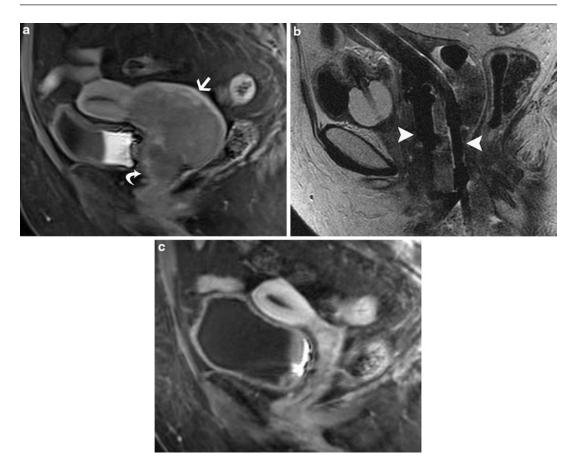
A 63-year-old woman with cervical cancer. Sagittal, enhanced MRI (a) shows a large enhancing mass (*arrow*) in the cervix extends inferiorly into the lower vagina (*curved arrow*). Sagittal T2-weighted MRI (b)
